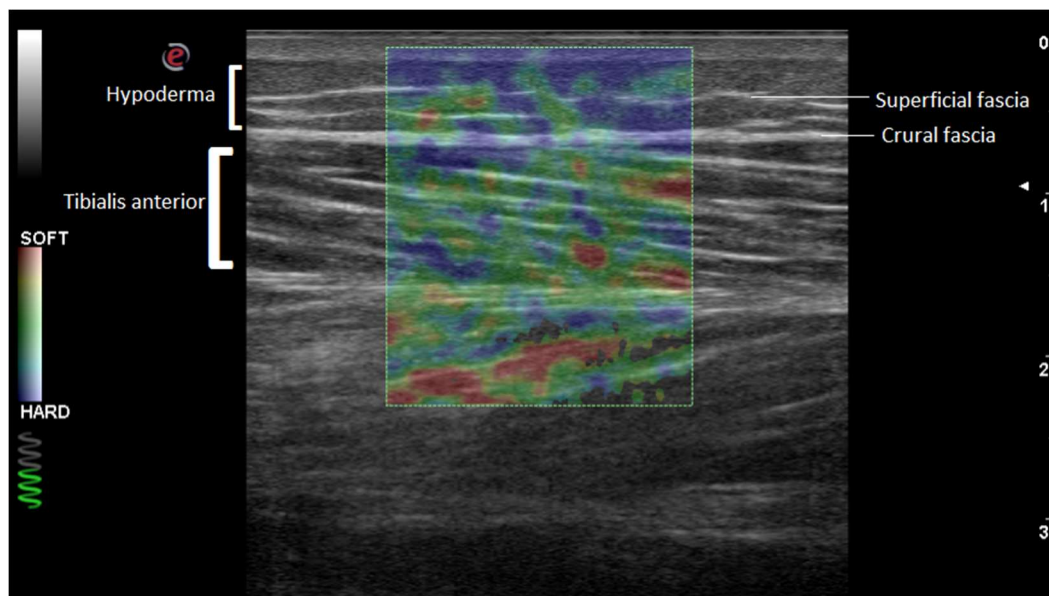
Ultrasonography and elastosonography (to assess tissue stiffness) imaging in a spastic tibialis anterior muscle.
